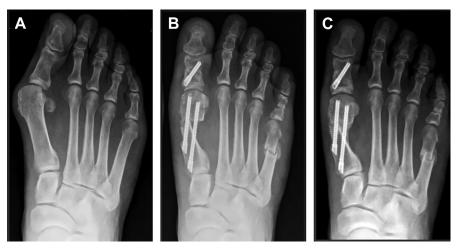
Radiographic series of a 64 year old male who underwent a transverse osteotomy MIBS. Preoperative (*A*), 06 weeks postoperative and (*B*) and 12 weeks postoperative (*C*) showing a good bone healing.
